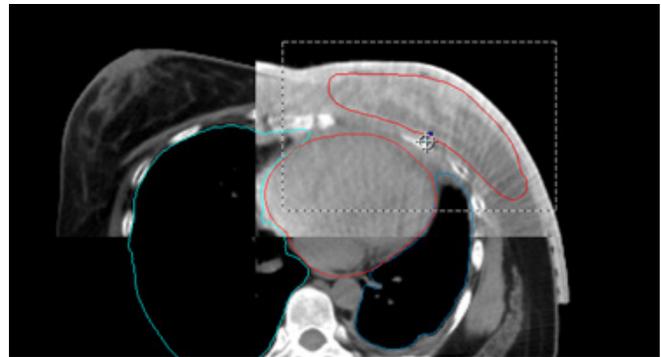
CBCT overlaid on the CT scan.
